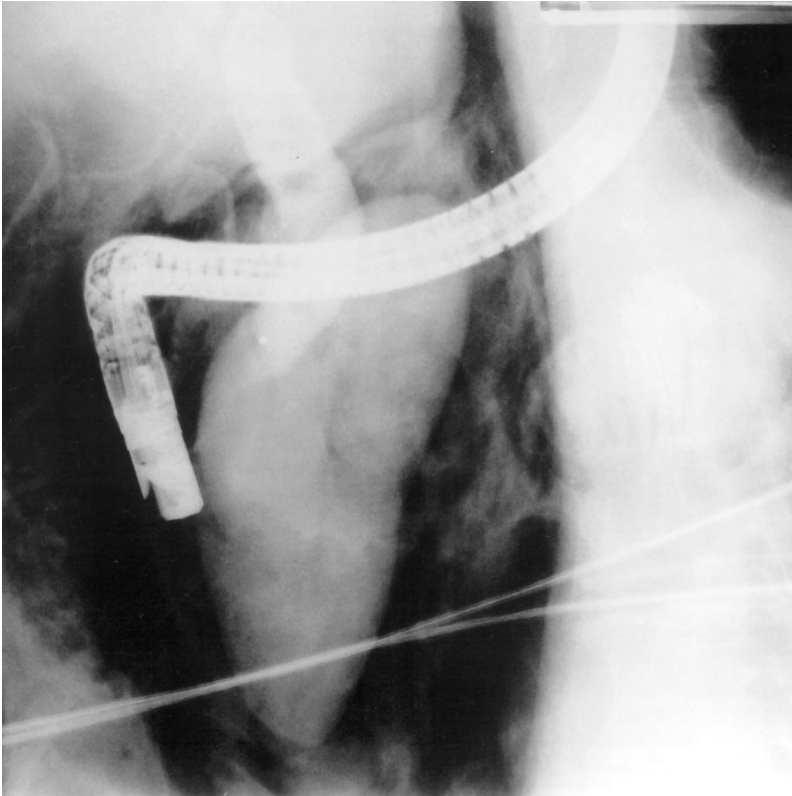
Plain film demonstrating a large leak (type I) after a duodenal perforation related to endoscopic retrograde cholangiopancreatography (patient 11).
